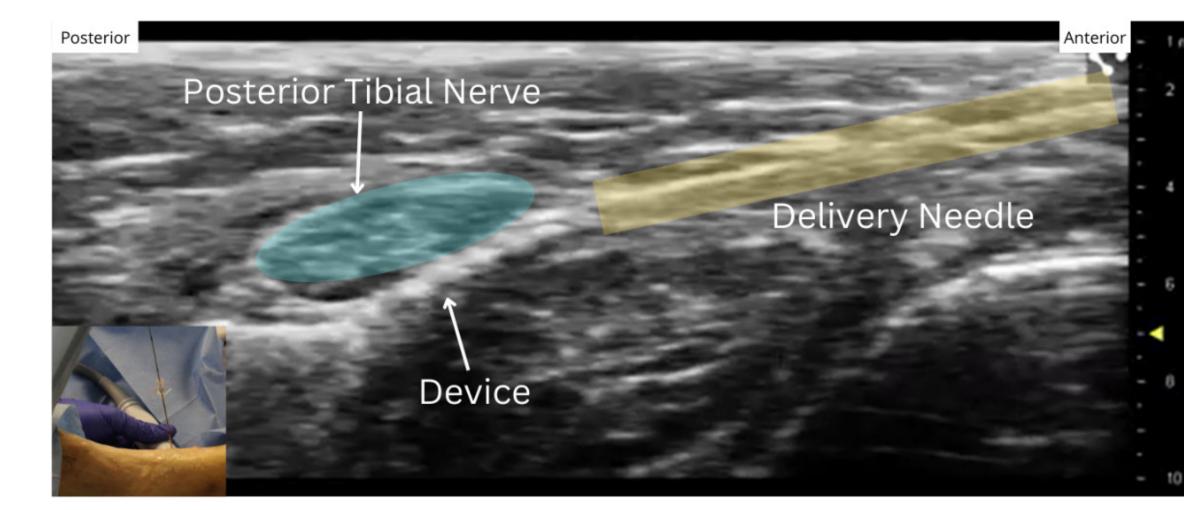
Ultrasound (Vevo 3100 MX450) visualization of the device exiting the delivery needle during injection, flexibly conforming to the PTN. Cut-down (right) confirmed accurate placement on the target.
